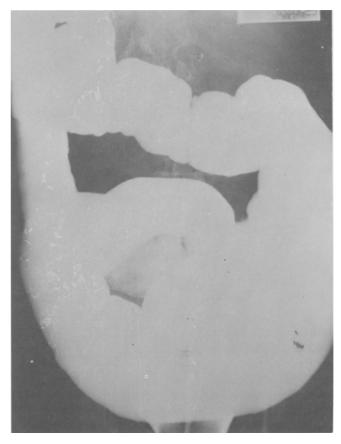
Barium-enema x-ray showing colon dilatation down to anorectal ring (Case 19).
